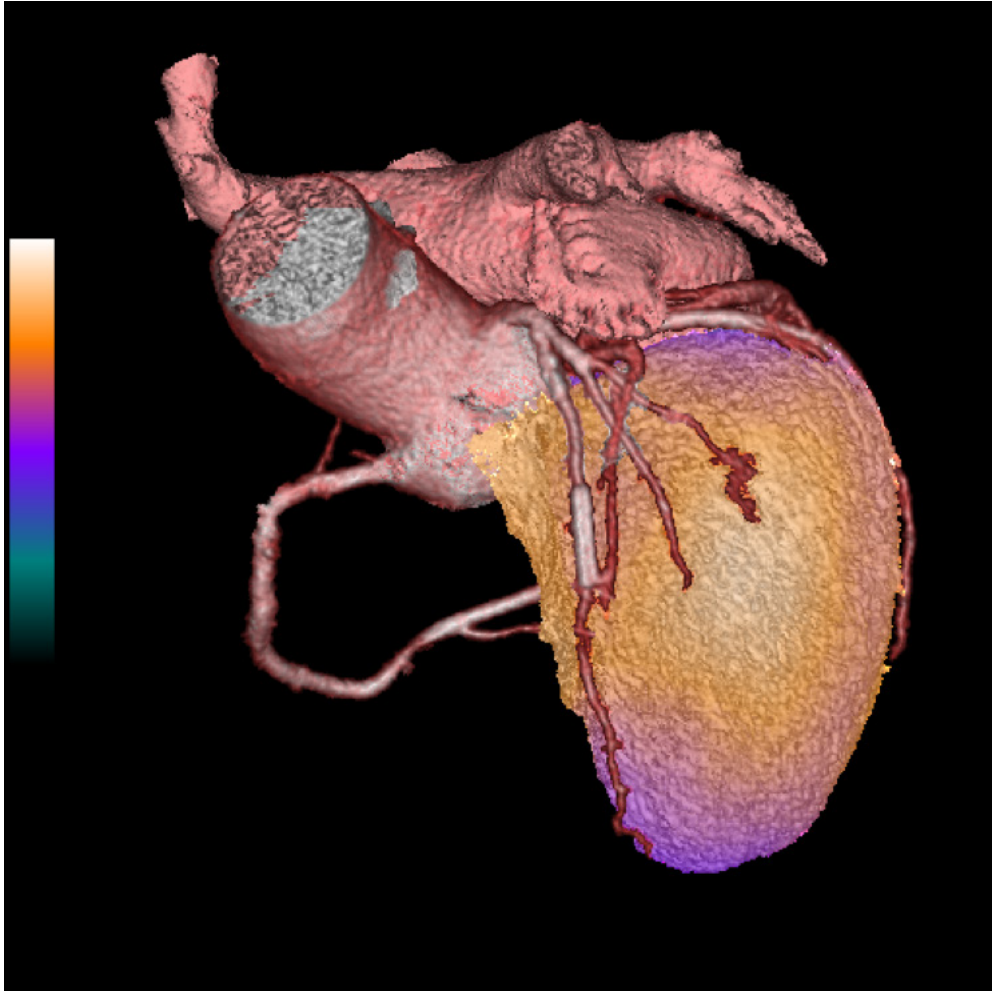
Combined emission perfusion scan and CT coronary angiography performed in the same imaging session.
